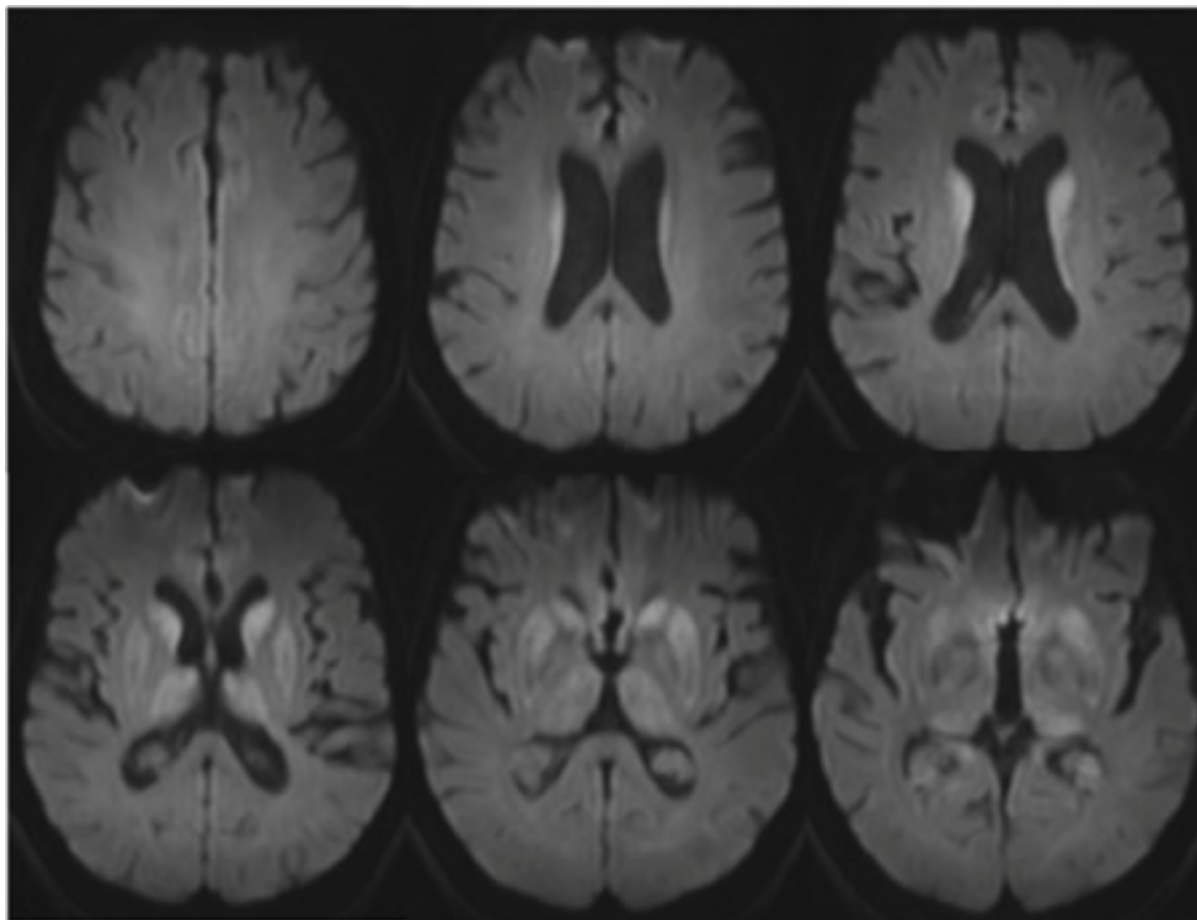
MRI brain: the pulvinar sign (a term referencing bilateral pulvinar hyperintensity) in a patient with Creutzfeldt-Jakob disease on diffusion-weighted images
